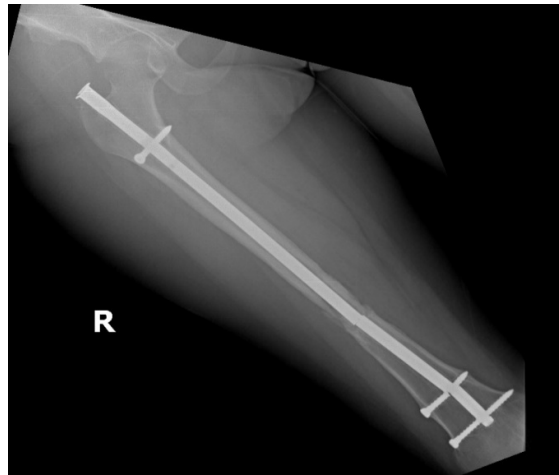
The plain radiograph showing the three-part broken femoral nail with delayed union of fracture
